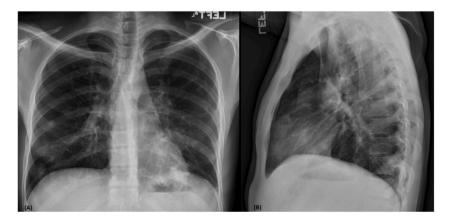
Chest X-ray showing patchy increased density in the left lower lobe, lingula, and right middle and lower lobes.
